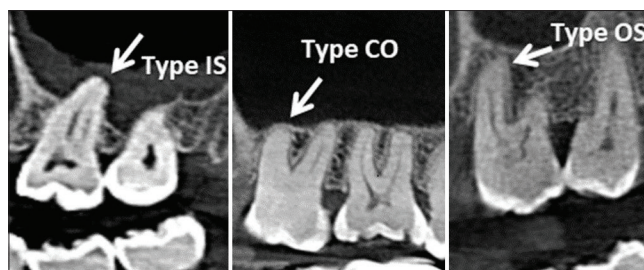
Cone-beam computed tomography images of three vertical relationships between maxillary posterior teeth and maxillary sinus floors
